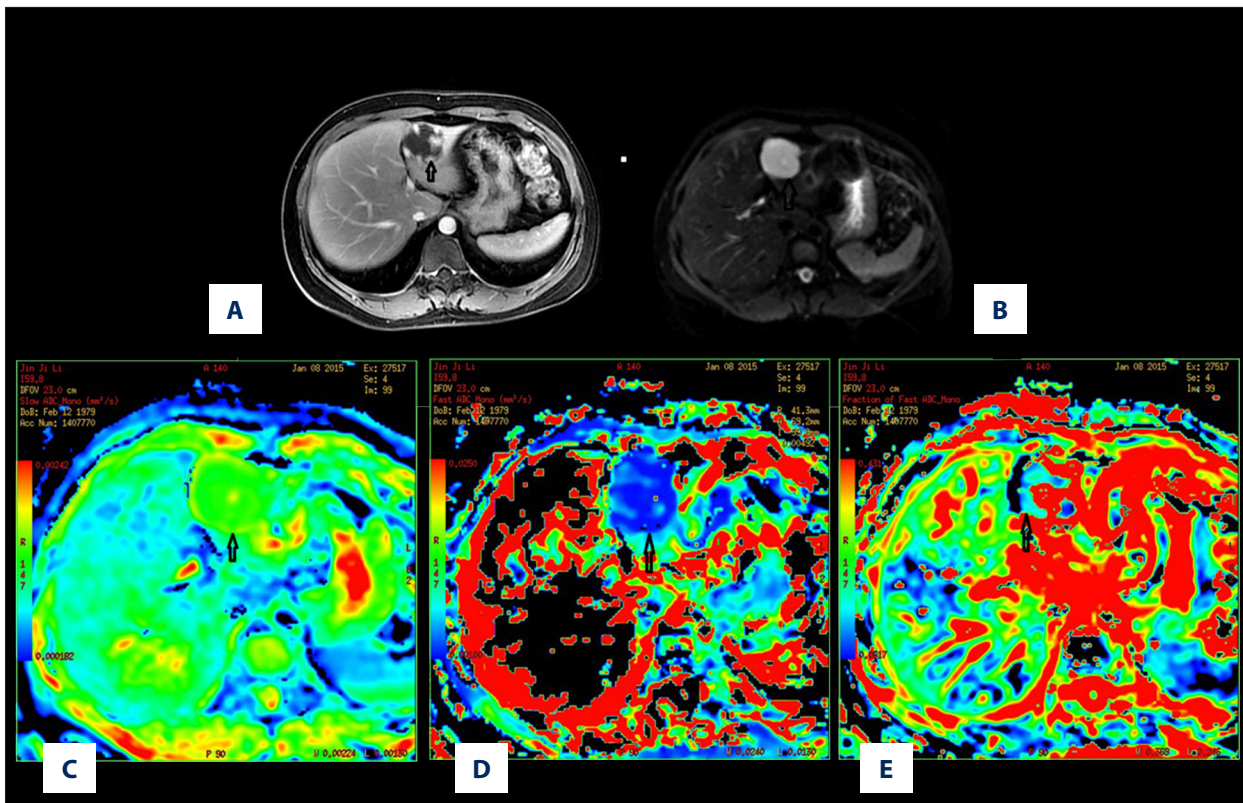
A 45-year-old female patient with hepatic cavernous hemangioma. (A) Contrast-enhanced DWI during the delayed phase showing a multi-nodular enhancement on the edge of the lesion located in segment III of the liver. (B) Mapping of the signal intensity of the lesion is much higher than hepatic parenchyma when $b=0$ s/mm². (C) Mapping of the estimated value of the D parameter. The average value in the lesion ROI was $D=2.27 \times 10^{-3}$ mm²/s. (D) Mapping of the estimated value of the D* parameter. The average value in the lesion ROI was $D^*=15.3 \times 10^{-3}$ mm²/s. (E) Mapping of the perfusion-related diffusion fraction (f) with a value of 33.3%.
